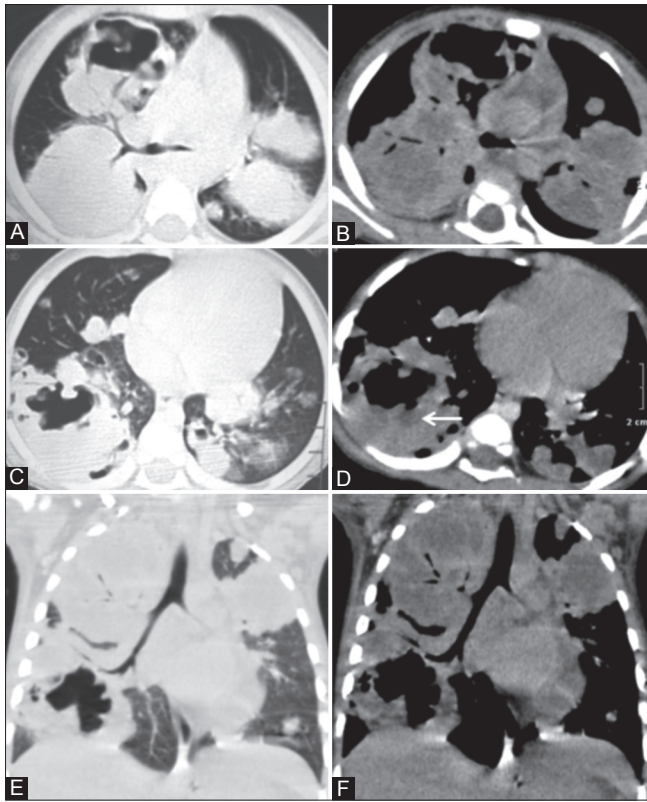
(A-F): Axial (A-D) and coronal reformatted (E, F) high-resolution computed tomography (HRCT) and contrast-enhanced (CECT) thorax images show multiple large nodular and cavitary lesions, with some of them showing fluid levels (straight arrow) randomly distributed in bilateral lung parenchyma representing pneumonic consolidations as well as disseminated abscesses. Few infiltrative peri-cavitary nodules are also noted
